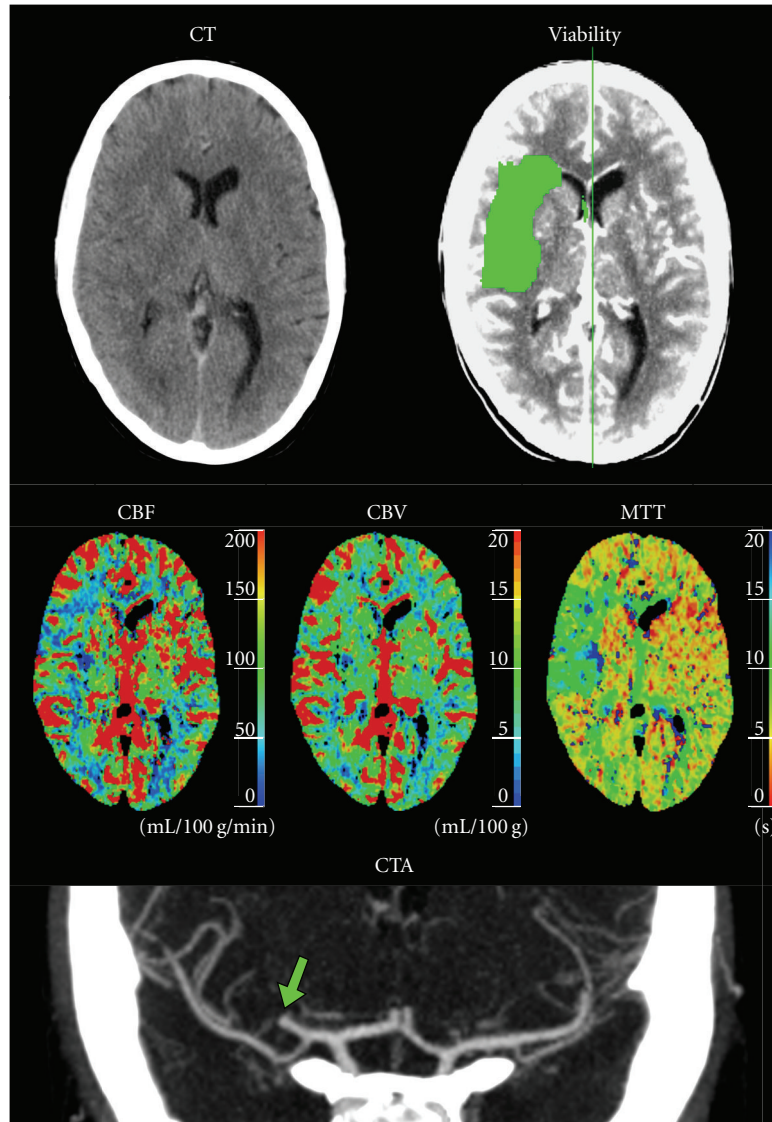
Case 4: 27-year-old woman with left-sided stroke symptoms of unknown onset and a normal NECT. The CTP viability map showed no ischemic core but a relatively large penumbra (green) in the right basal ganglia caused by a M2-segment MCA occlusion (arrow) seen on the CTA.
